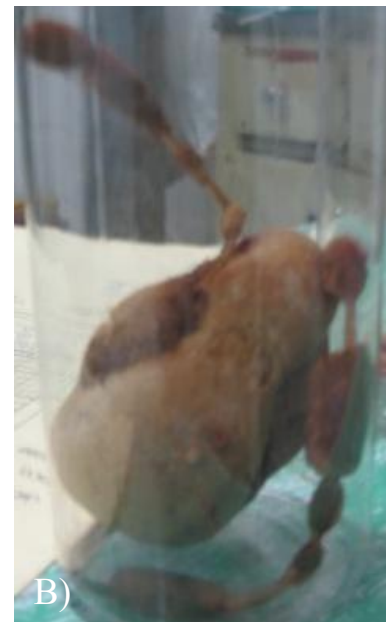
A) KUB radiograph view of associated stone burden and 5 yrs old encrusted fragmented DJ stent, B) bladder stone with encrusted DJ stent removed
